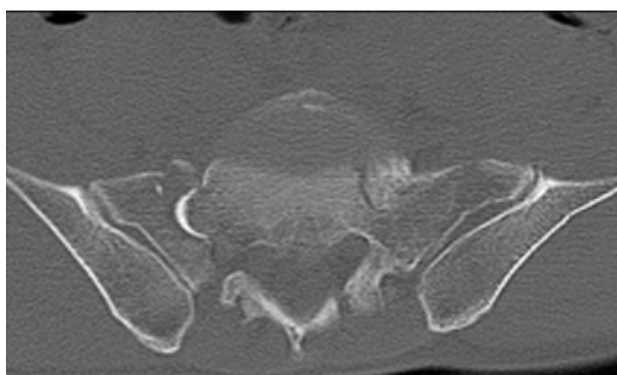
Coronal CT cut showing fractures of the bilateral sacral ala
